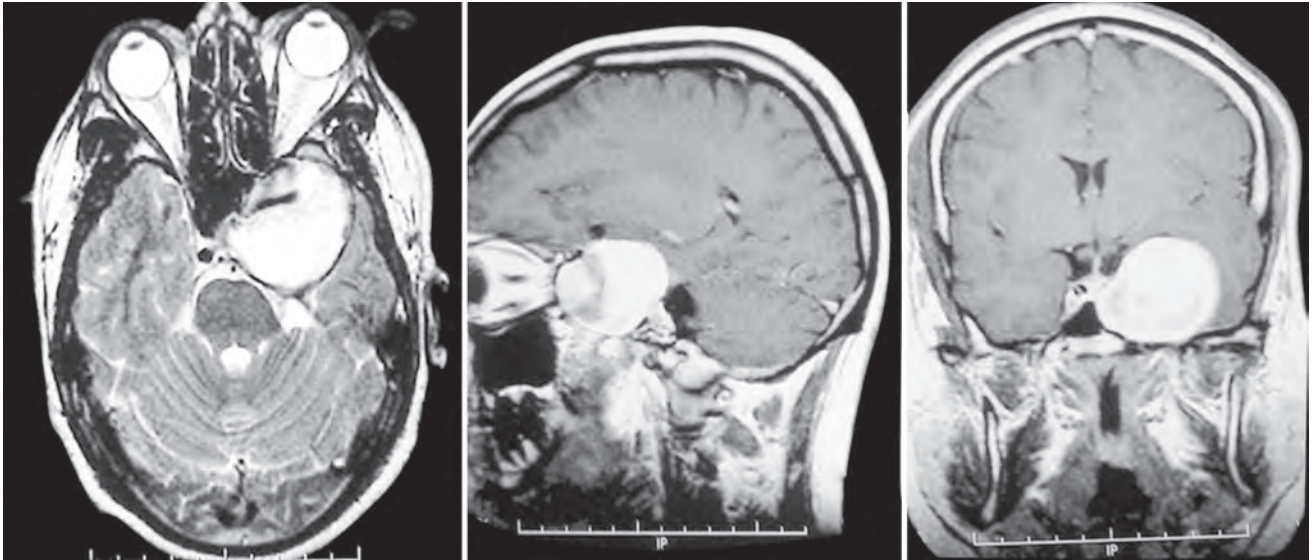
Axial T2 and sagittal and coronal T1-weighted MR images showing a giant cavernous and paraclinoid transitional aneurysm
